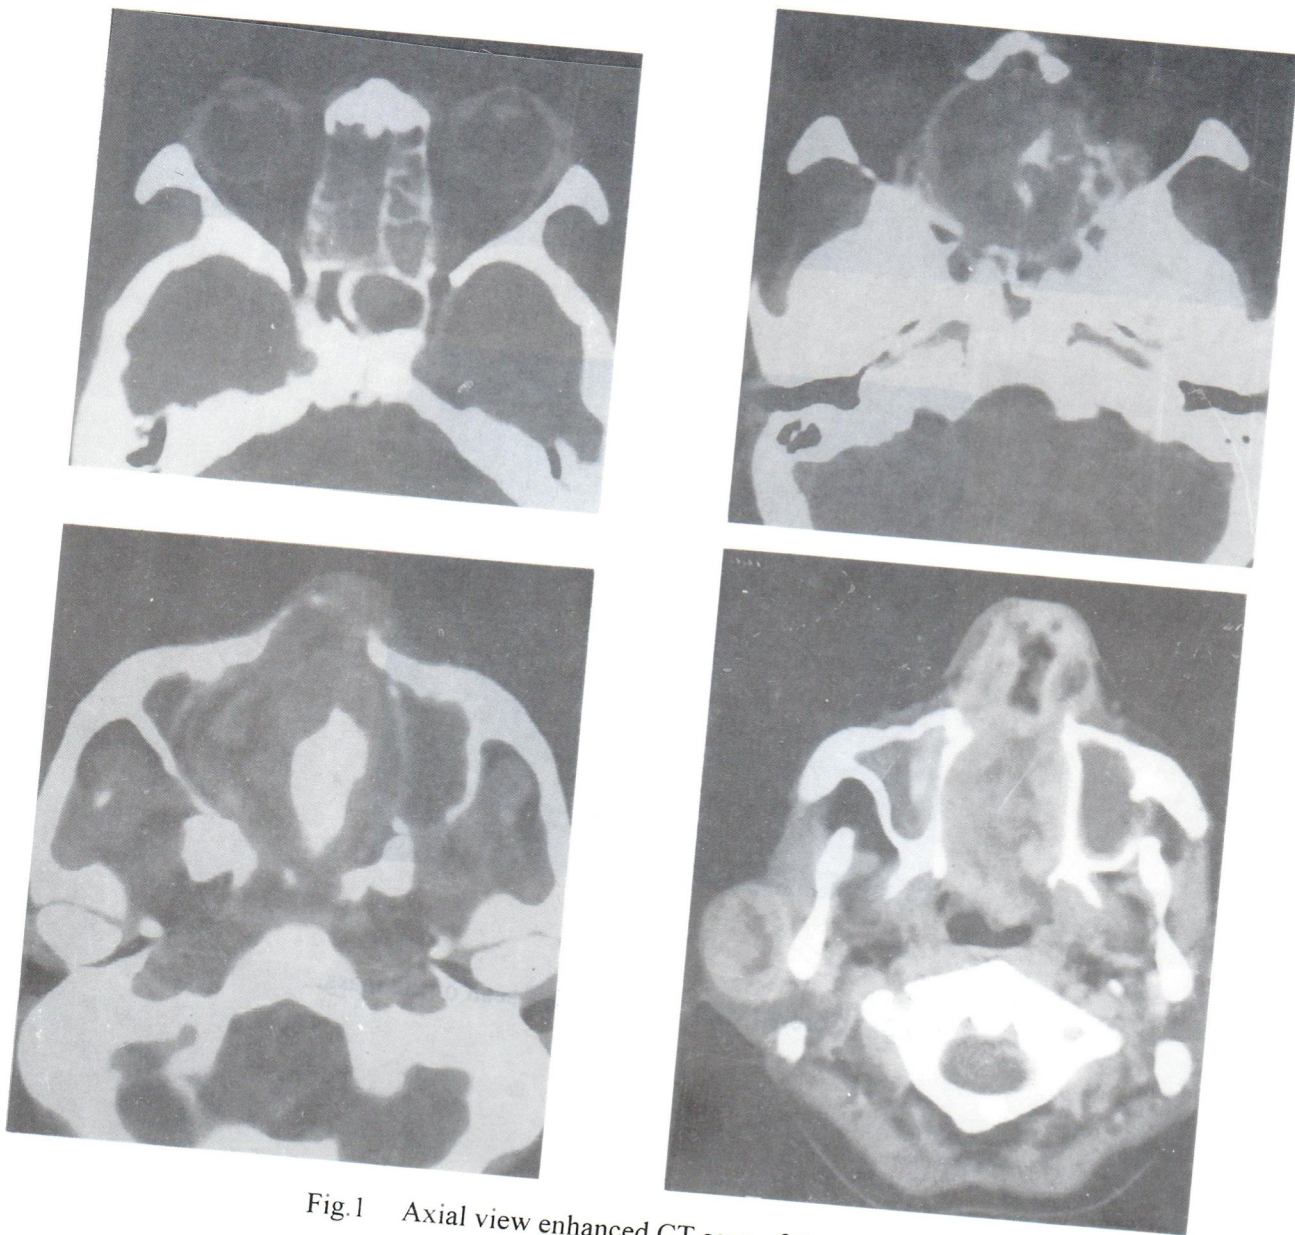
Axial view enhanced CT scan of the mass
